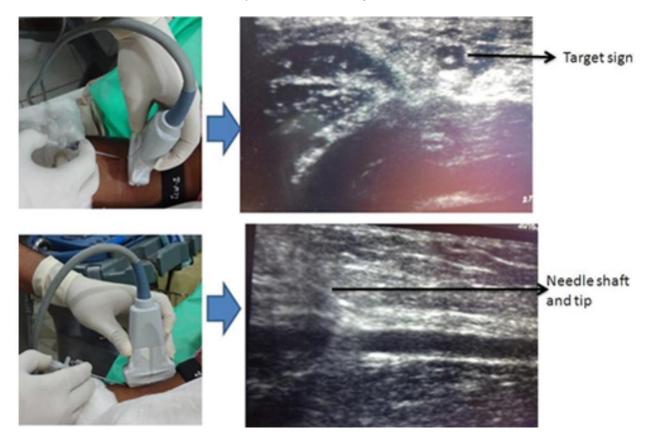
The top is a depiction of an ultrasound guided peripheral IV placement in the axial plane. The "target sign" refers to visualization of the needle tip within the target vein in the axial plane. The bottom figure shows the same ultrasound guided technique using the linear plane along the course of the target vein. The advantage of this method is the ability to see the needle tip and shaft, as well as a longer segment of the target vein.
